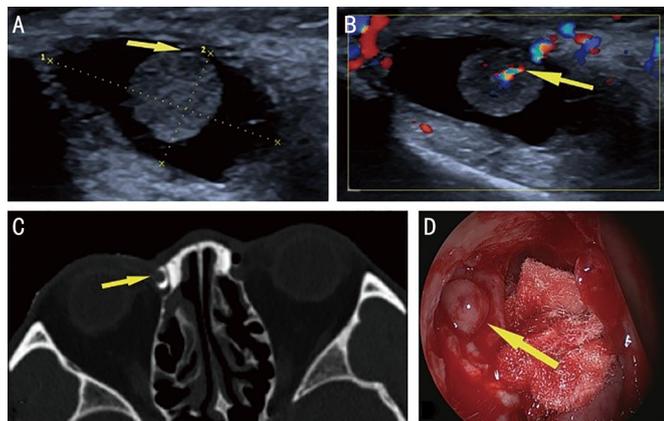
Imaging features of polyps in CDU and CT-DCG A: A round-like with uniform internal echo and a clear margin was detected during the conventional ultrasound. The yellow arrow shows the narrow connection between the base of mass and the wall of the lacrimal sac. B: CDU showed lined blood flow signal inside of mass. C: CT-DCG showed a round filling defect of soft tissue density connected to the lacrimal sac wall (yellow arrow). D: Smooth-surfaced, spherical-like soft tissue found during surgery (yellow arrow). CDU: Color Doppler ultrasound; CT-DCG: Computed tomography dacrycystography.
